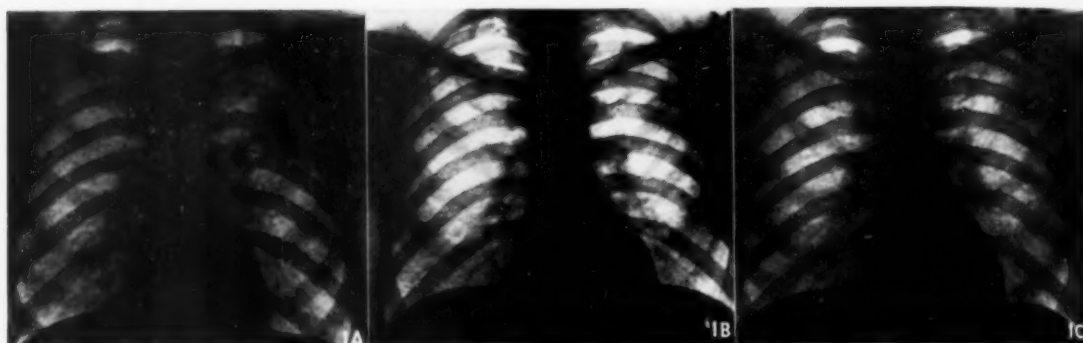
C.H.P., Indian male, 39 years. Penicillin, 33 mega-units over 11 weeks. Sulphadiazine, 61 g. over 11 days. Potassium iodide, 30 gr. daily over the whole course of treatment. Commenced work as gardener after 18 days of treatment. Symptom-free in 39 days. Faint scar on X-ray in 81 days. No change on X-ray 1 month later.
